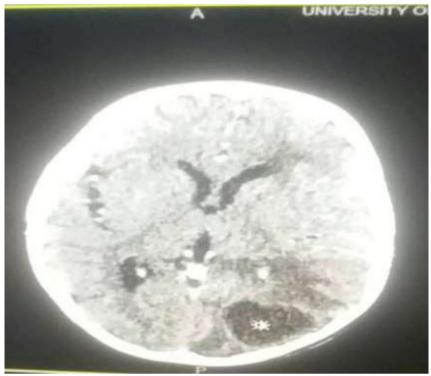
Contrast-enhanced cranial CT (axial section) showing a hypodense lesion with thin uniform ring-like enhancement and perilesionaloedema in the left occipital region.
